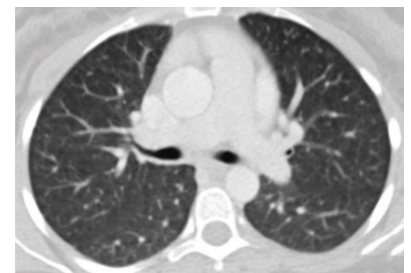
Axial chest CT with intravenous contrast injection at the level of the lower lobes, resolved completely 5 years later
